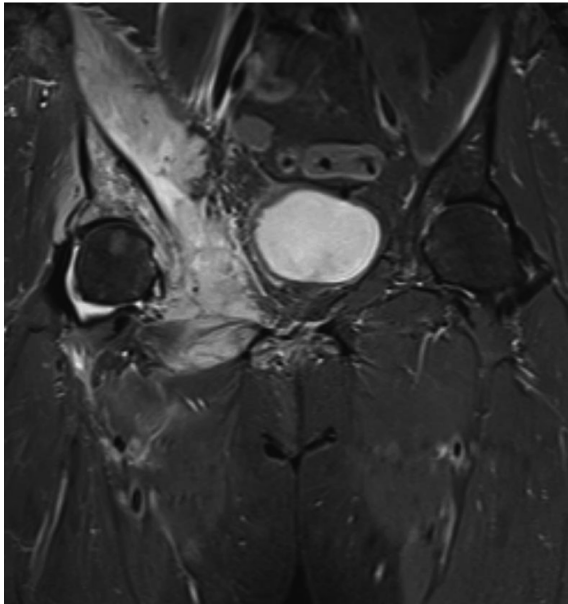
Pyomyositis of left thigh at its purulent stage (multiple abscesses formation) with septic arthritis; magnetic resonance imaging coronal short-time-inversion-recovery image showed multiple abscesses from left buttock and also in left upper thigh; septic arthritis of left coxofemoral joint with loss of joint spaces, erosions, bone marrow edema of femoral head.
